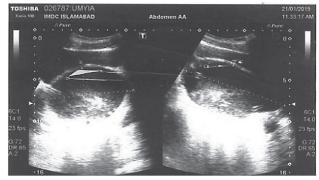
Ultrasound of pelvis showing mass due to hematocolpos
